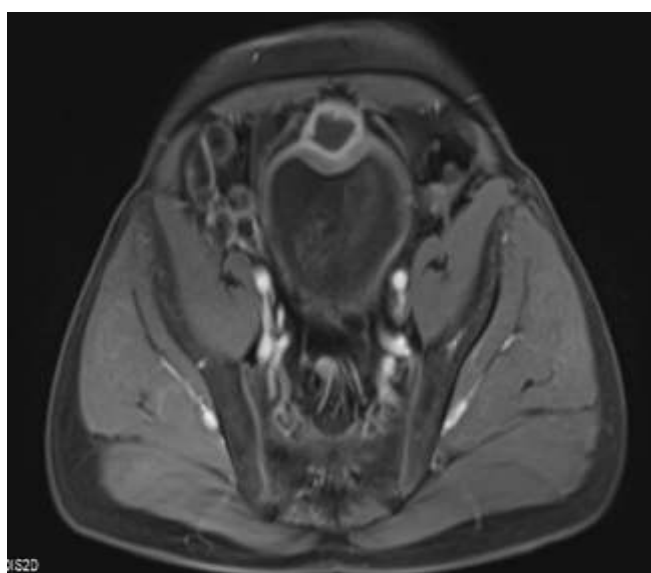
Axial post-contrast T1-weighted image: Intense peripheral enhancement of the tract wall, confirming an active inflammatory process
